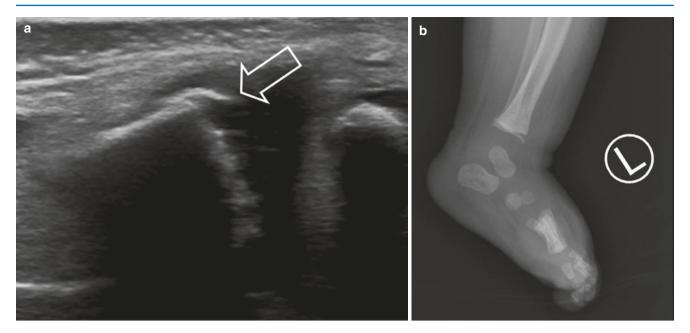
(a) Ultrasonography of the distal tibia shows a metaphyseal corner fracture (b). Corresponding conventional radiograph of the ankle
